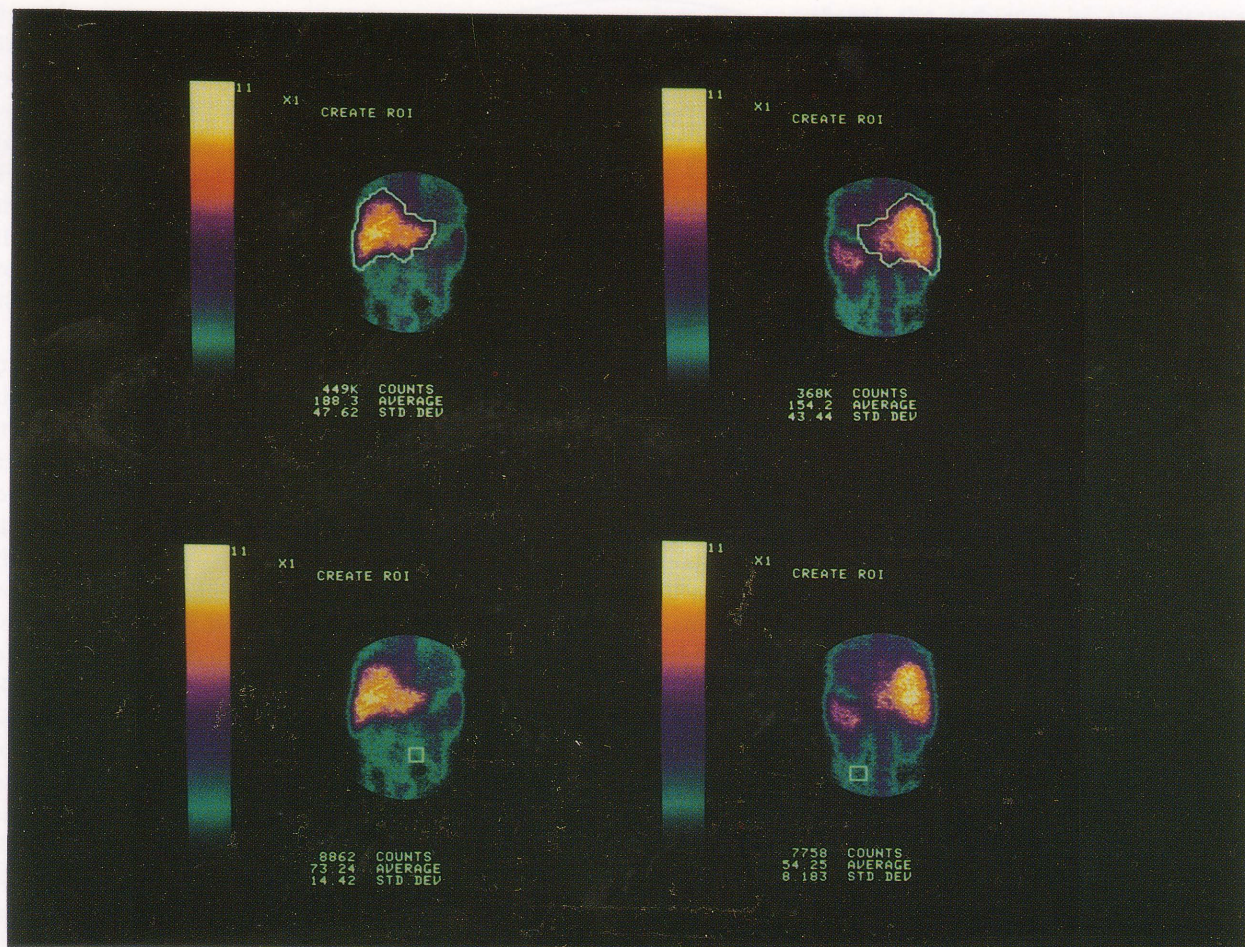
Immunoscintigrams of the abdominal region. Left sides are anterior and right sides are posterior views. The upper row images represent liver ROIs for the calculation of liver uptake. The lower row images represent the background ROIs which served as a reference in eliminating the background activity included in the liver ROI. The same ROI was used from the day of injection to 5 days after injection.
